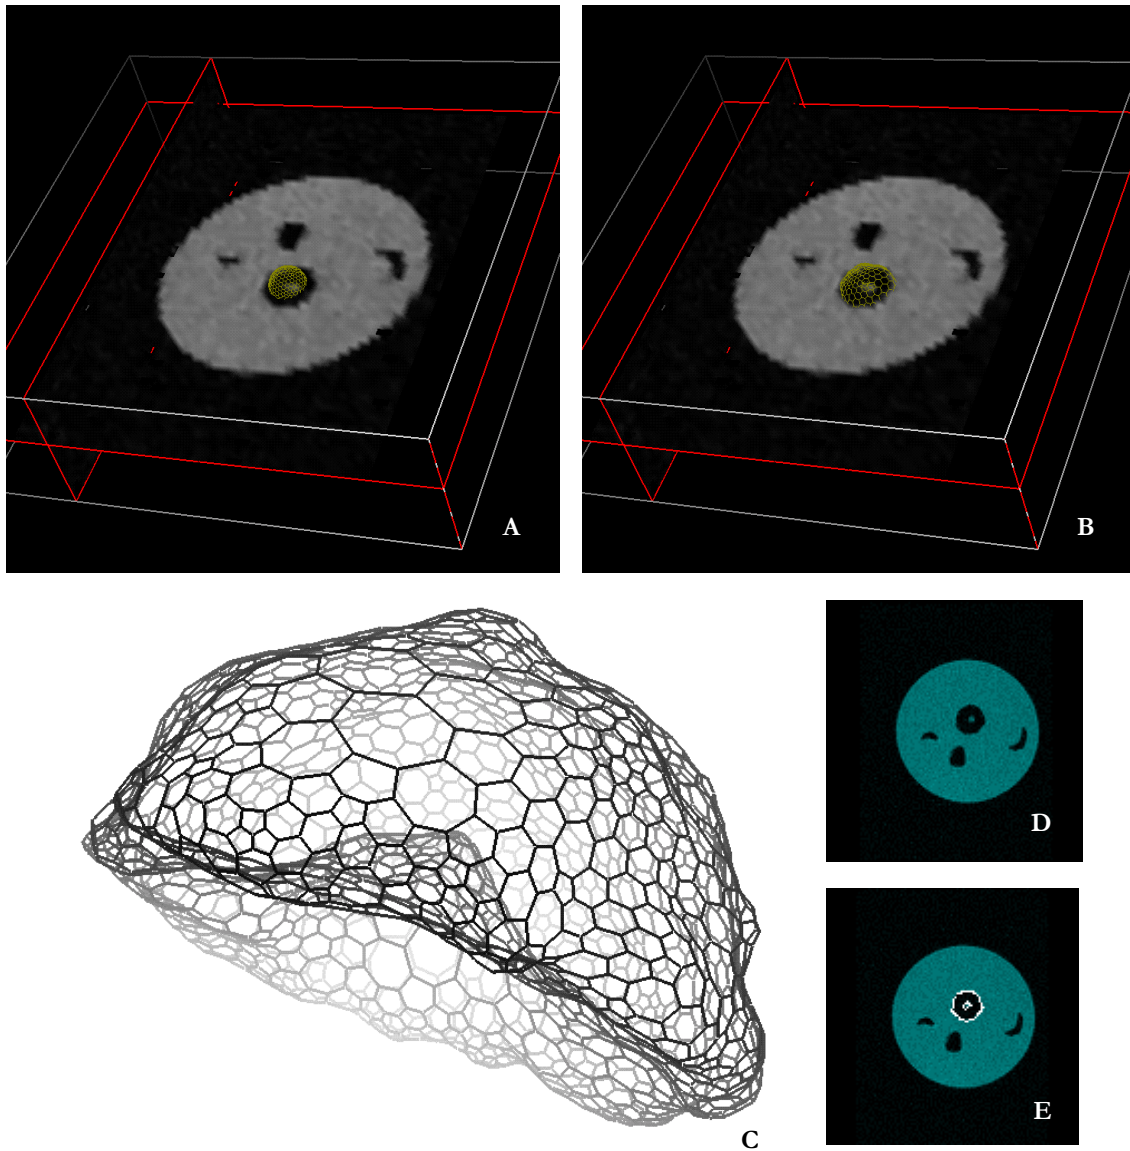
Simplex mesh fitting process: A) Original mesh (sphere) superimposed on a 2D slice of the MR volume; B) the mesh is locking on to the boundary; C) refined mesh; D) one slice of the target MRI data, showing a cross-section of the object to be segmented at top (cf. section 3.10.2 for details), and E) intersection of the resulting mesh with the slice.
